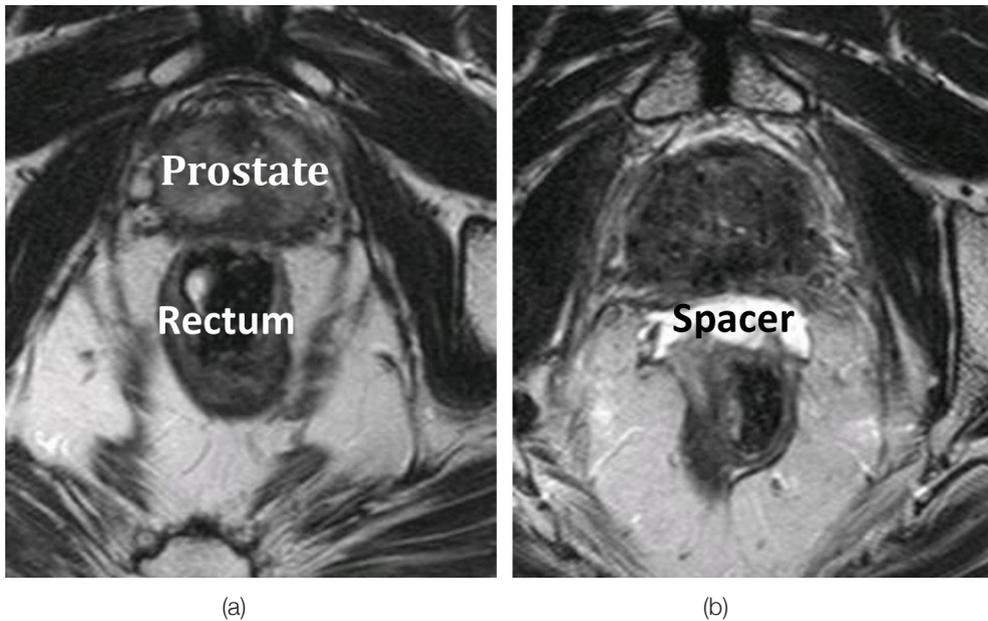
Axial T2-weighted magnetic resonance images of a patient with a hydrogel spacer before injection (a) and after injection (b)
